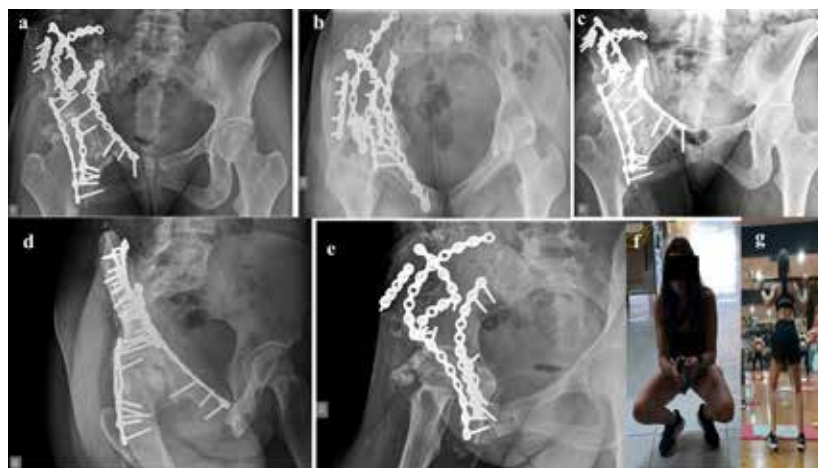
Case 3. 1 year clinical + radiological follow up. No signs of OA and head sits well *a)* AP Xray, *b)* Inlet, *c)* Outlet, *d)* Obturator oblique, *e)* Iliac oblique, *f, g)* fully functional patient doing sports
